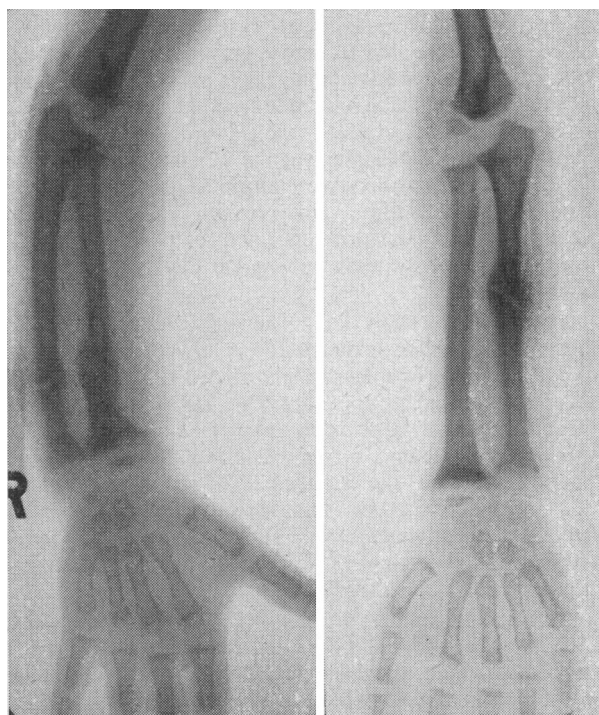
Case 15. Radiograph showing active rickets with fractures of radius and ulna.
